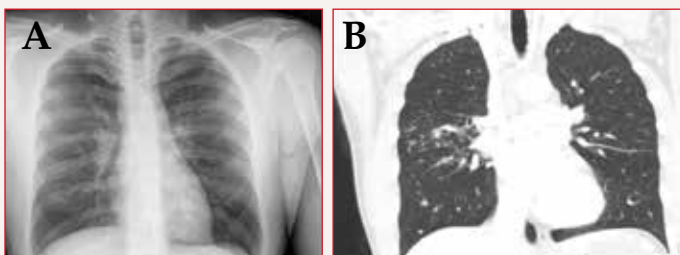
(A) Chest x-ray demonstrating mild bilateral hilar and right paratracheal adenopathy, with subtle micronodular pattern in the upper lobes. (B) Chest computed tomography scan showing enlarged lymph nodes in the mediastinum and hila and pulmonary nodules.
